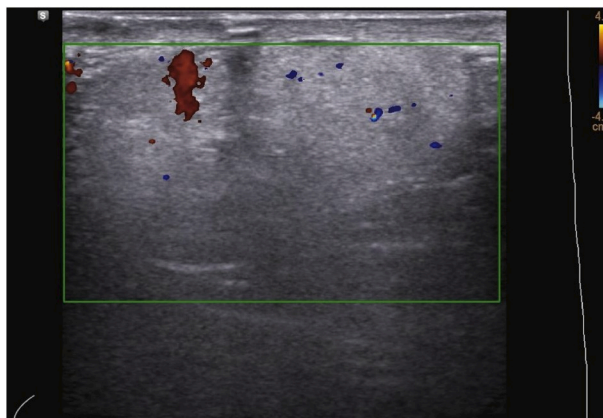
A slightly hyperechoic zone in the ultrasound CDFI image.
